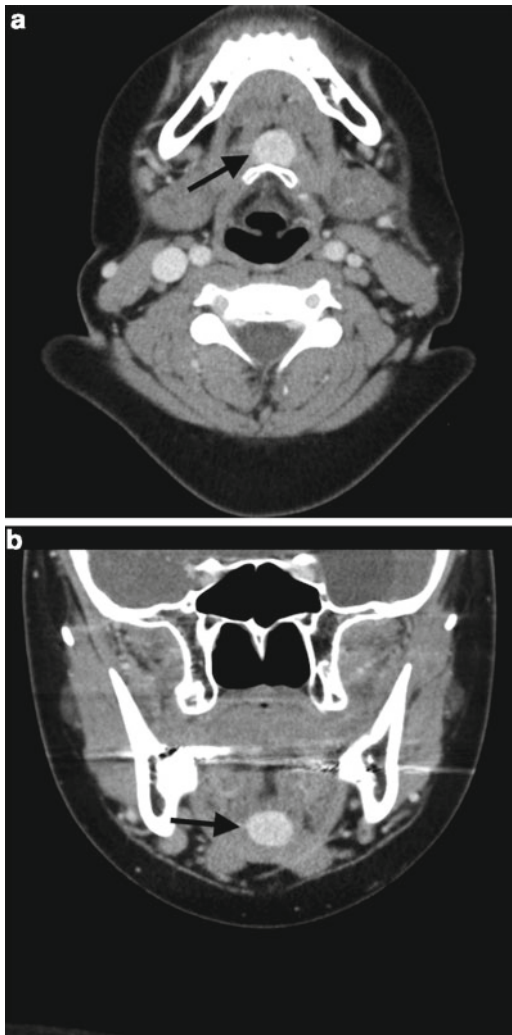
Ectopic thyroid. Aberrant thyroid tissue may be found anywhere along the course of the thyroglossal duct, from the base of the tongue to the thyroid bed. Although scintigraphy is often espoused as the study of choice to identify ectopic thyroid tissue, it provides little spatial resolution. CT has the advantage of significantly better spatial resolution and the ability to provide multiplanar reconstructions, which can often better demonstrate rest of aberrant tissue, as shown in this patient with hypothyroidism, no thyroid tissue in the thyroid bed, and a small rest of aberrant thyroid (*arrows*) anterior to the hyoid bone.
